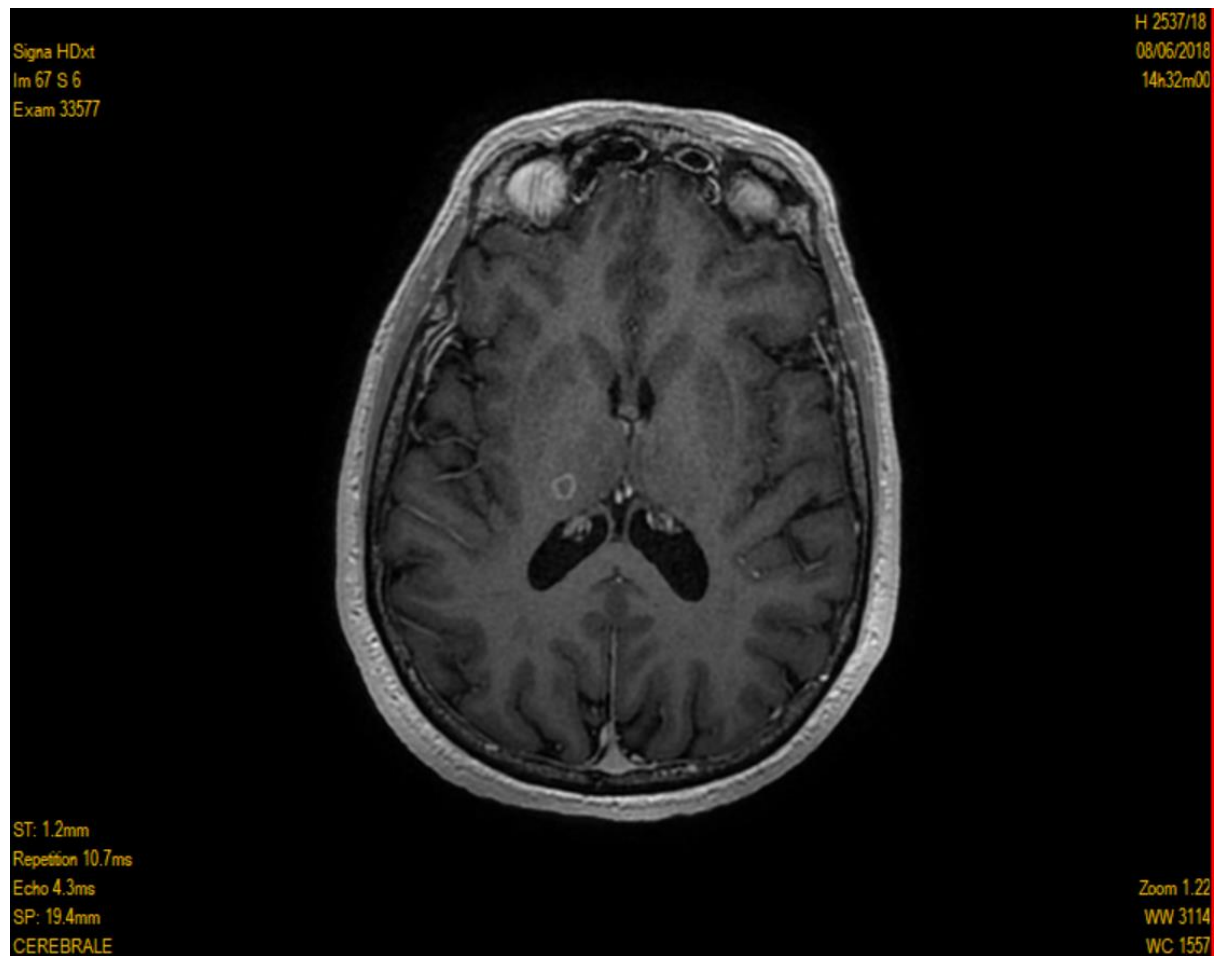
Axial sections of cerebral MRI in injected T1 sequence showing toxoplasmic abscesses: hypointense T1 lesions with target-like enhancement, at the level of typical locations: grey matter-white matter junctions and central grey nuclei.
